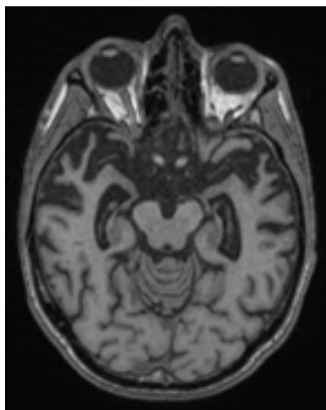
Cortical and hippocampal atrophy T1-weighted image
